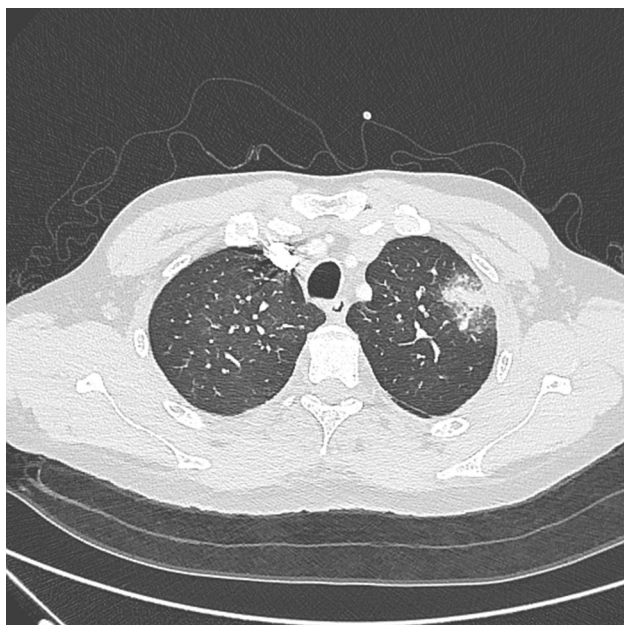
A 37-year-old man who had diarrhea, fever, chills, cough, vomiting, and sore throat. Chest computed tomography scan showed an infiltrate in the left upper lung lobe
